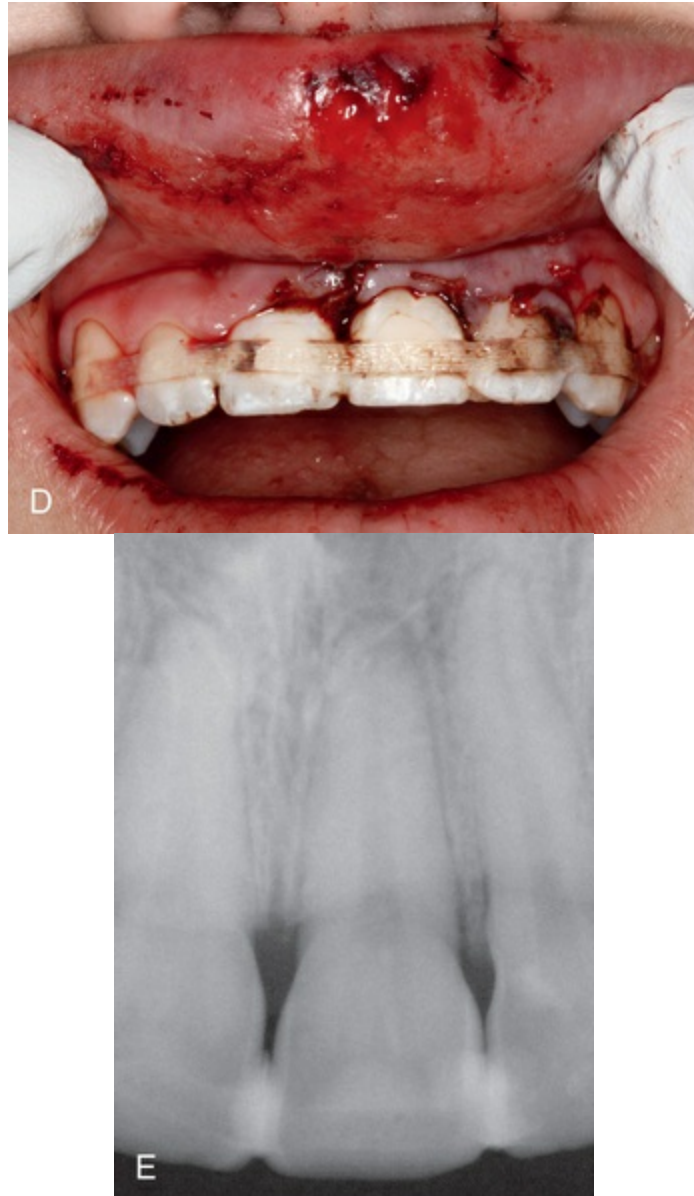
(A) Initial examination of the patient. (B) Trauma site following irrigation. (C) Replantation of avulsed and luxated teeth. (D) Replanted and splinted teeth. (E) Radiograph after placement of the splint
